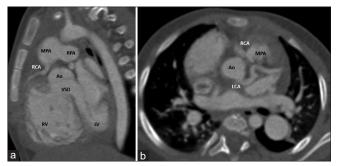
CT scan sagittal (a) and axial (b) views showing the left coronary artery and the anomalous right coronary artery from the pulmonary artery. AO: Aorta, MPA: Main pulmonary artery, RCA: Right coronary artery, LCA: Left coronary artery, RPA: Right pulmonary artery, RV: Right ventricle, LV: Left ventricle, VSD: Ventricular septal defect
